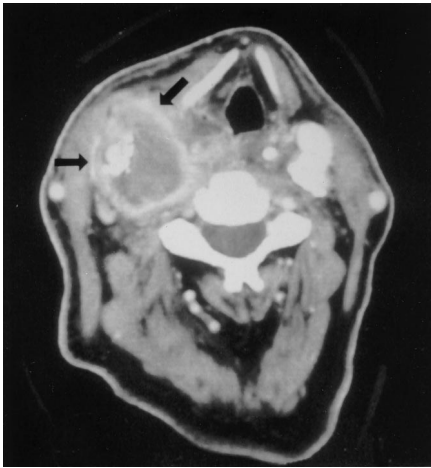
Computed tomographic scan of the neck showing a 4- × 4.5-cm rim-enhancing lesion originating from the posteromedial aspect of the carotid bifurcation (arrows). The hypodense peripheral component represents thrombosed blood, and the hyperdense center (2 cm) represents fresh blood. Significant inflammation surrounds the mass.
